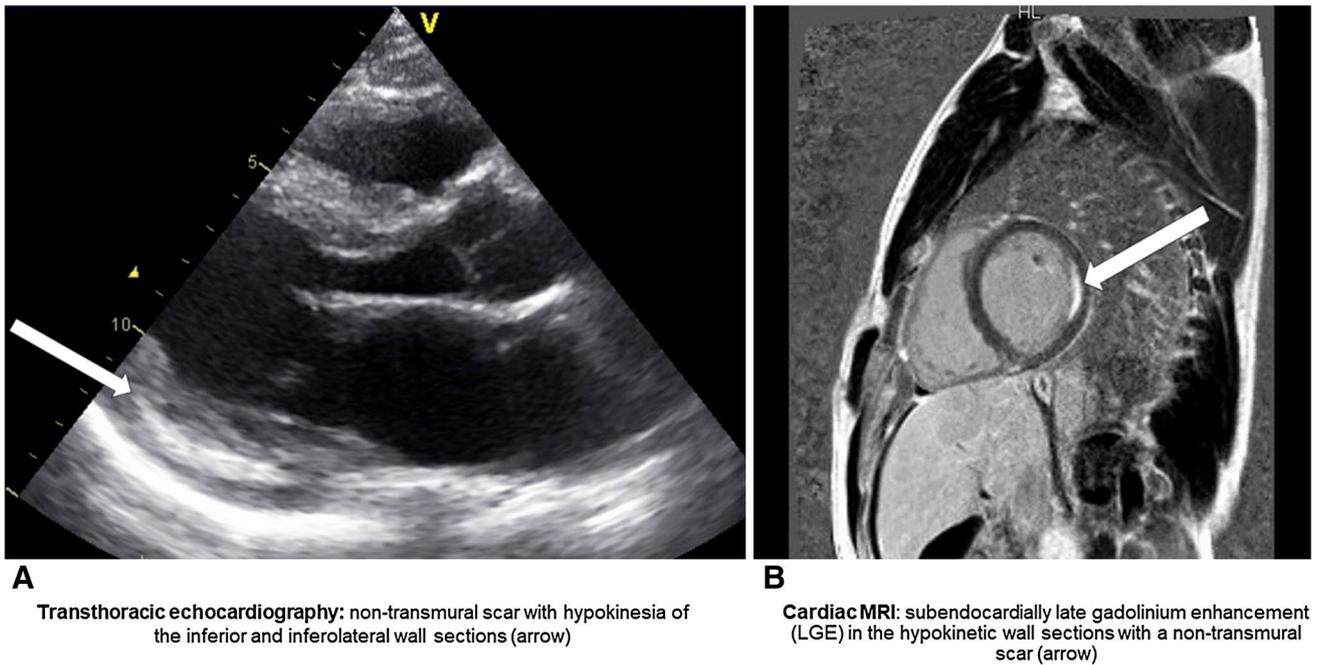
Cardiac imaging studies, consisting of transthoracic echocardiography (a) and cardiac MRI (b)
